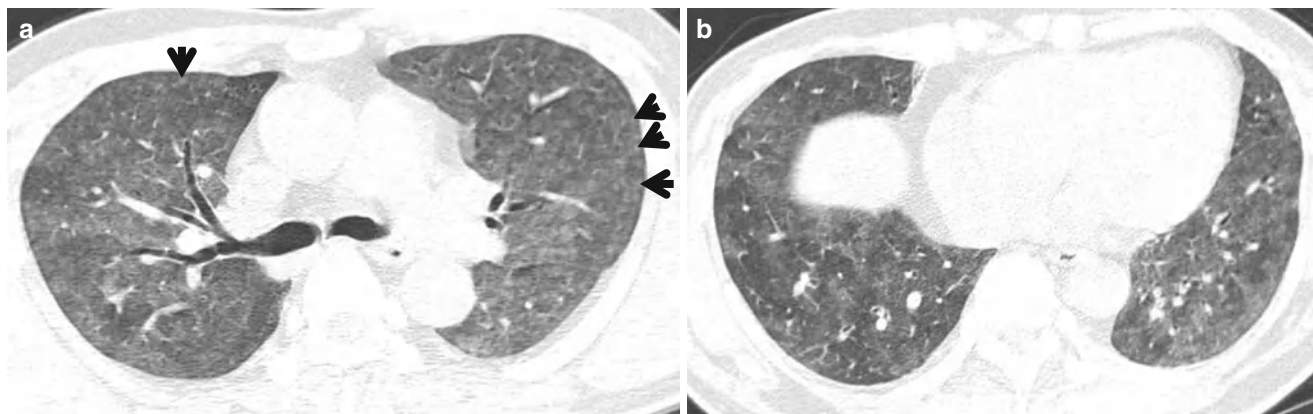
Acute hypersensitivity pneumonitis in a 53-year-old farmer man. (a, b) Lung window images of CT scans (1.5-mm section thickness) obtained at levels of right upper lobar bronchus (a) and liver dome
